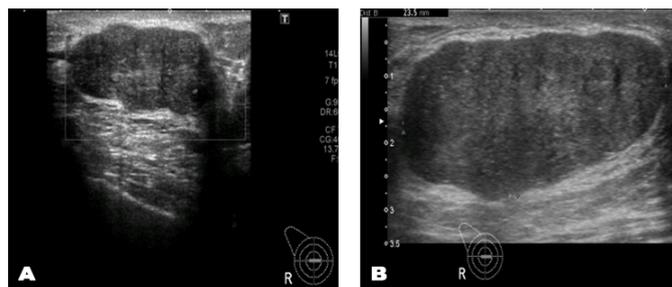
(A and B): Initial ultrasound of right breast showing a solid heterogeneous lesion with lobulated margins and internal vascularity in retroareolar region measuring 42x32 mm (A). Follow-up ultrasound showing same lesion with increase in size (B).
